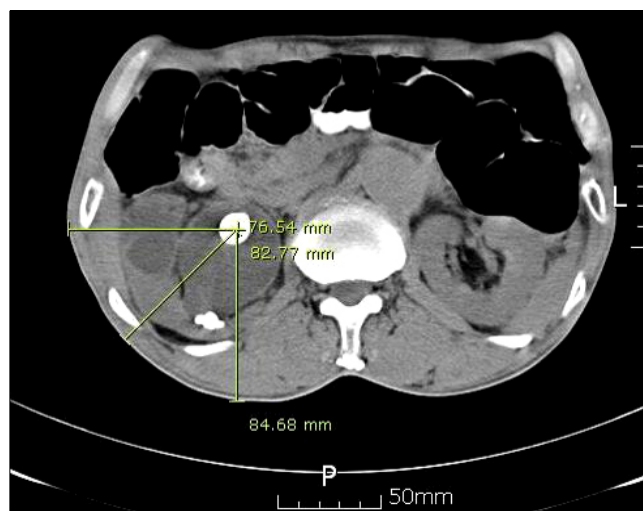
Measurement of the skin-to-stone distance at 0°, 45°, and 90° on an axial scan of NCCT. NCCT: non-contrast computed tomography.
